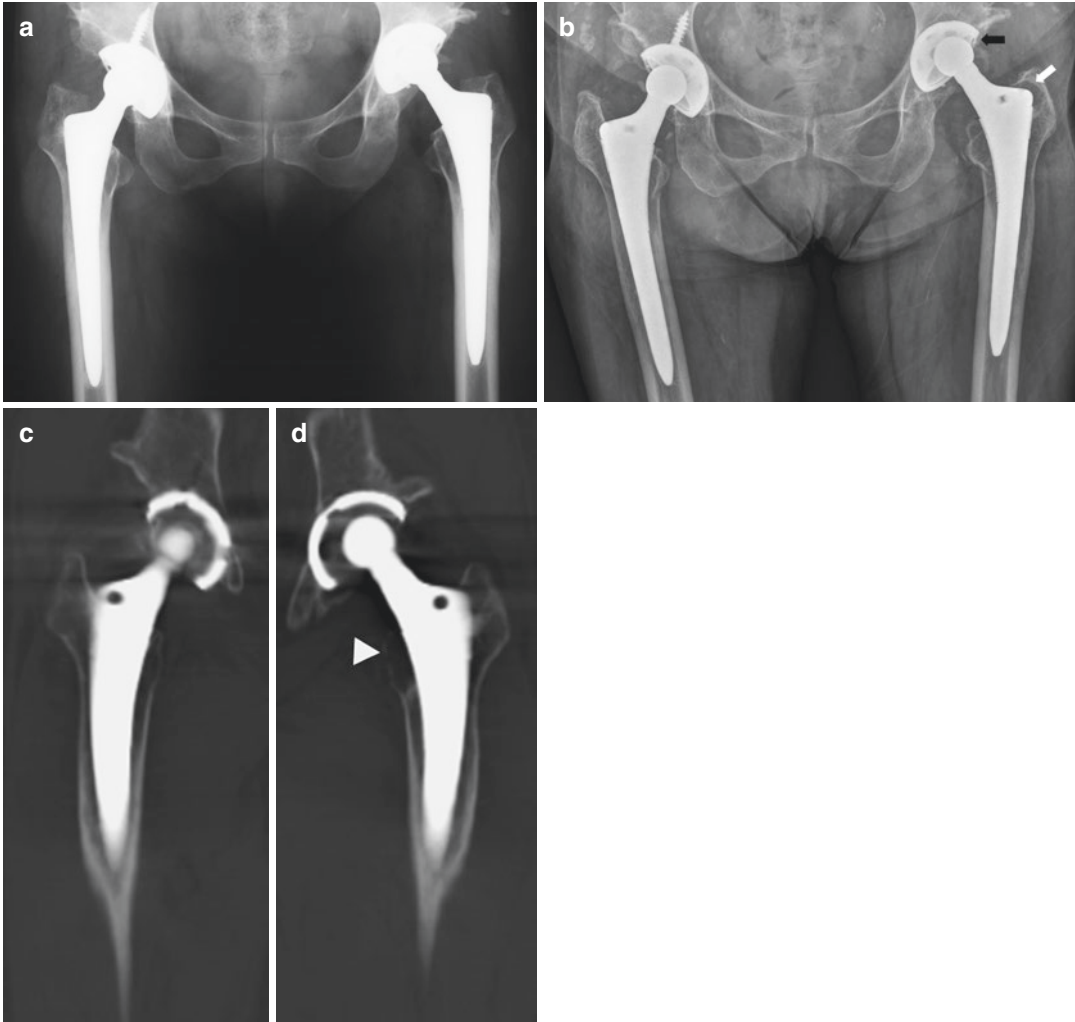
(a) A 50-year-old woman underwent THA using conventional polyethylene on the left hip due to osteoarthritis. One year later, she underwent THA on the right hip with the use of HXLPE. (b) Radiograph at 19 years after left THA (18 years after right THA) shows
